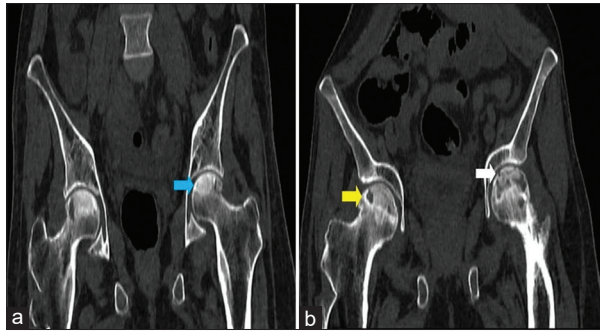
(a) Computed tomography abdomen (bone window) showing sclerosis of bilateral femur head (blue arrow) (b) showing cortical break (white arrow) and subchondral cysts (yellow arrow)
